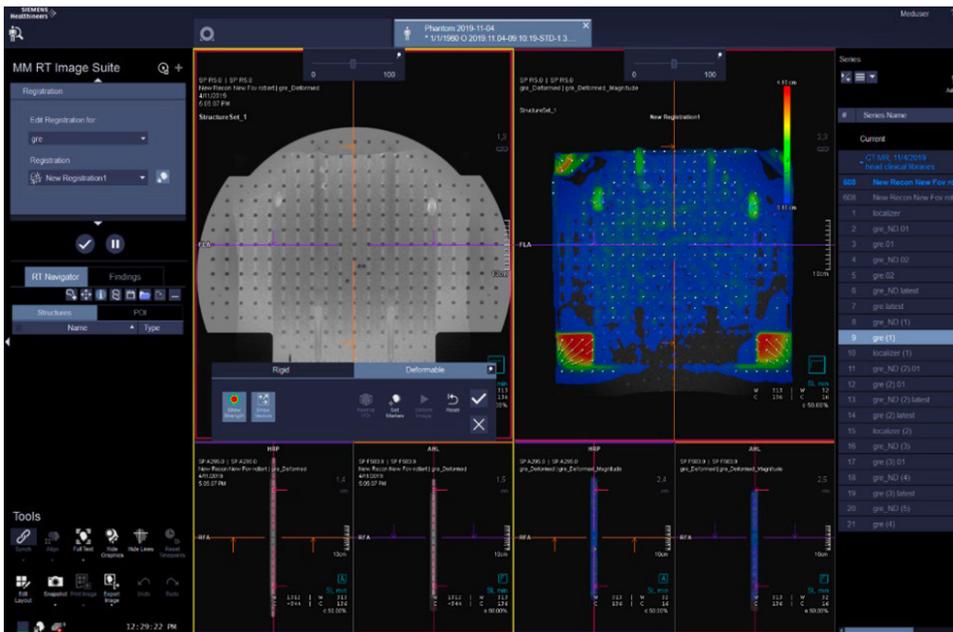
Deformable registration within syngo.via RT Image Suite, of MR and CT images, for visual comparison
